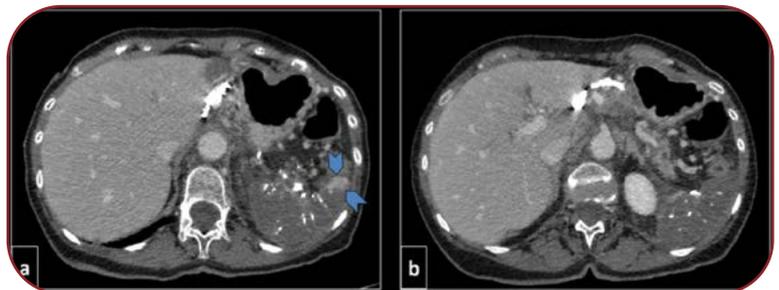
Follow-up CT, obtained prior to discharge three days later, displays no significant change. No contrast enhancement was apparent in the splenic parenchyma (a, b), apart from a small parenchymal isle (arrowheads) (a).
